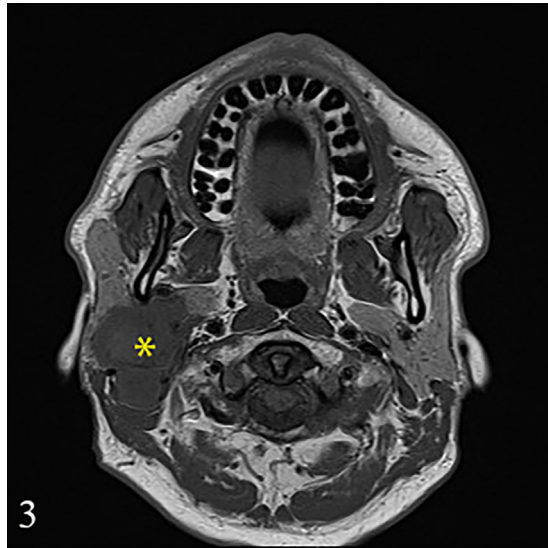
The T1-weighted axial image revealed a homogeneous iso intensity lesion (asterisk) compared with the spinal cord.
